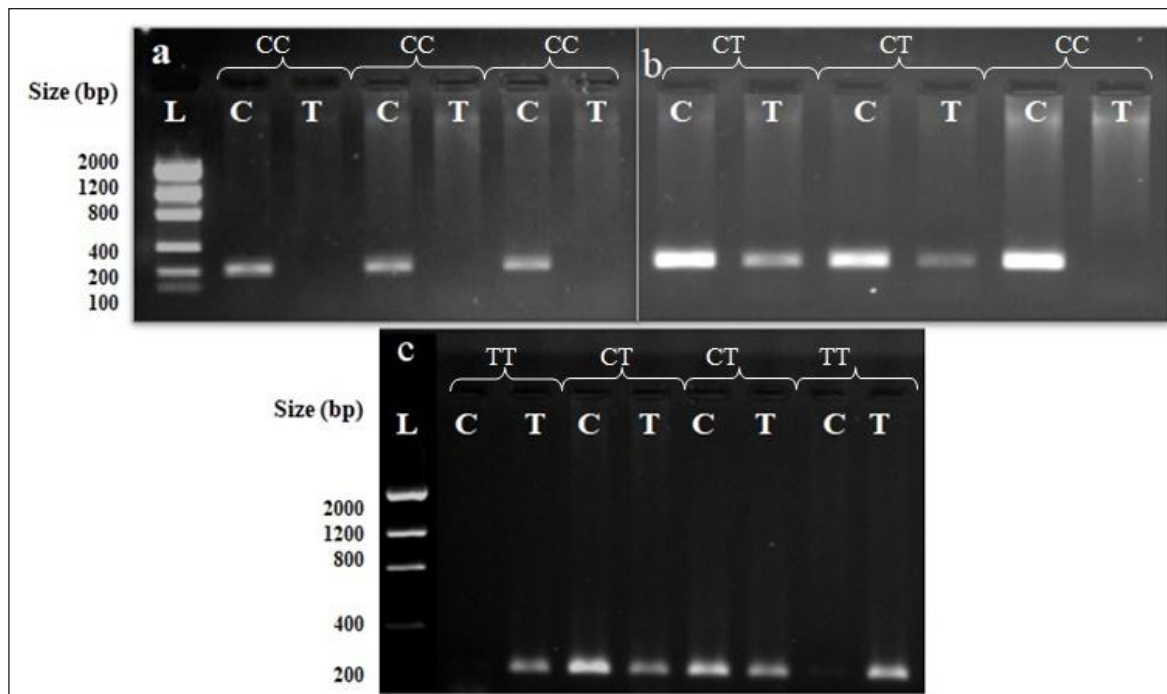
PCR products resolved on agarose gels showing genotyping of rs7903146 (C/T) by allele-specific PCR assay. For each sample two parallel PCR reactions were designed, one with C allele primer, the other with T allele primers along with common reverse primer, and run in parallel on agarose gel (2%). A 205 bp band in Normoglycemic controls (a) and T2DM patients (b, c) represented all three genotypes (CC/CT/TT). In agarose gel, the first lane with standard 2 Kb DNA ladder (L) and other lanes with parallel C/T indicated for the product of similar individual amplified from PCR reactions.
